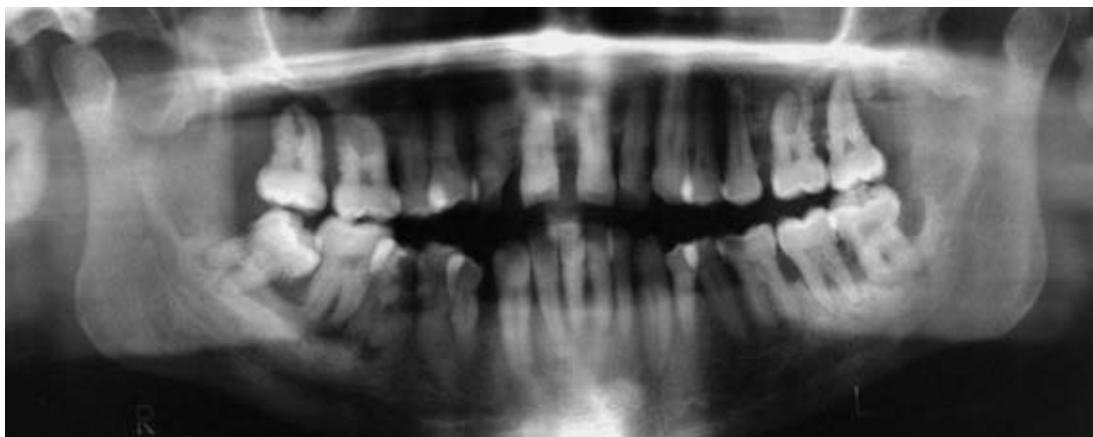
Orthopantomogram of the patient, showing large amount of bone loss.
